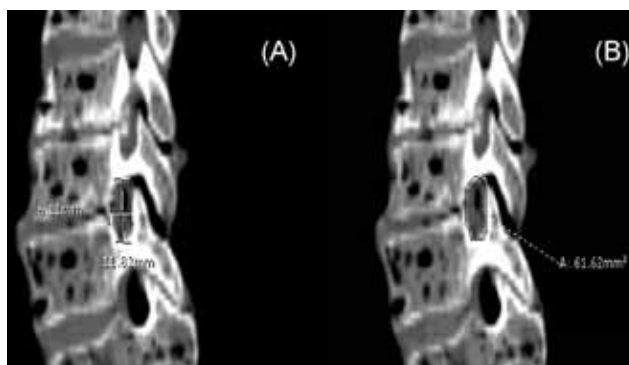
(A) Calculation of foramina height and width from oblique computed tomography image using digital radiography software. (B) Calculation of foramina area using freehand measurement tool.
